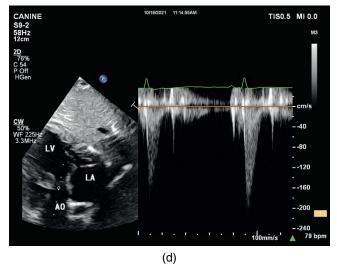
(*Continued*) (c) Spectral Doppler of the aorta can also be obtained from the subcostal view, lining the Doppler cursor up parallel to the left ventricular outflow tract and aorta. (d) Aortic flow is recorded with PW or CW Doppler. With PW, the gate is placed in the aorta just distal to the aortic valve. The spectral display to the right shows downward flow below the baseline as blood exits the left ventricle.
